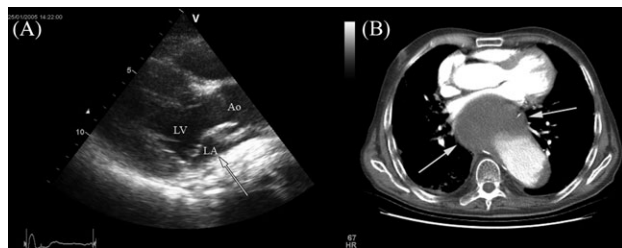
Transthoracic echocardiography (A) and computed tomography scan (B) of a 76-year-old patient with the symptoms of an obstructive shock. Analysis first with transthoracic echocardiography later with computed tomography scanning depicts a descending aneurysm with a large intramural hematoma (arrows on computed tomography scan) compressing the left atrium, having a maximum diameter of 13 cm. Inflow of the left atrium was severely compromised (arrow on TTE). LA, left atrium; LV, left ventricle; Ao, aorta.
